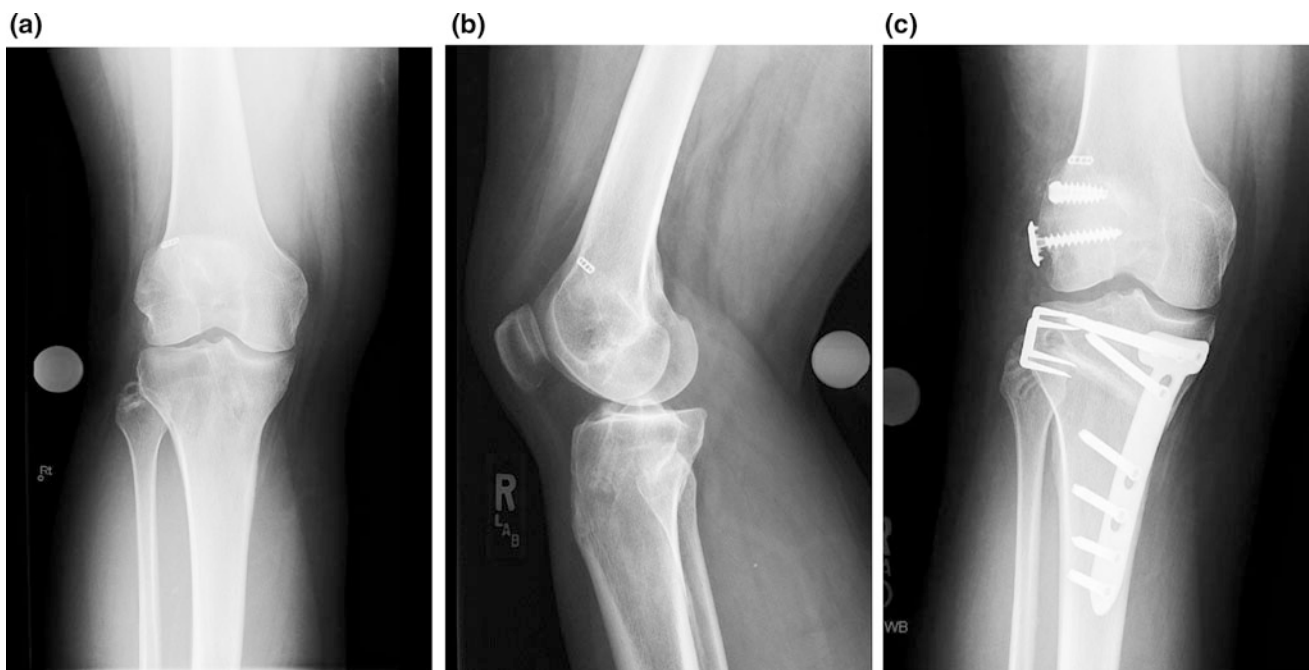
Twenty-eight-year-old male presenting right knee persistent instability with varus alignment after failed ACL and PLC. a Pre-HTO anteroposterior (AP) radiograph right knee; b Pre-HTO lateral
